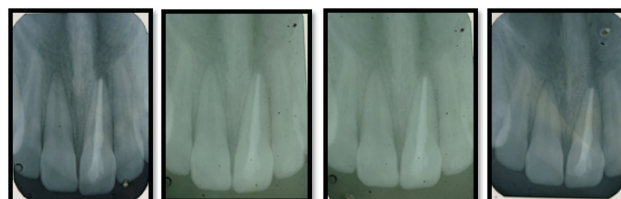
Radiographic follow up at 3 months, 6 month, 1 year and 2 years
